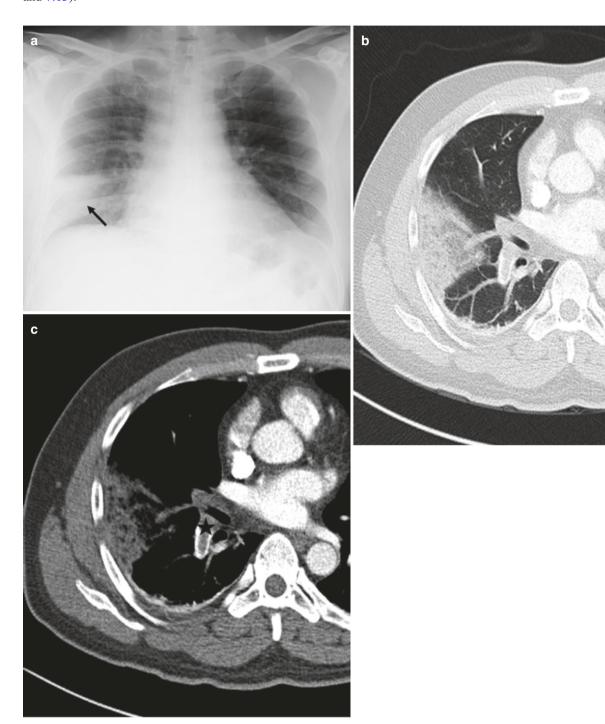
Hampton's hump. (a) Peripheral wedge-shaped opacity (black arrow) in right lower zone on AP chest radiograph in a patient with suspected pulmonary thromboembolism. (b, c) Axial CT images
